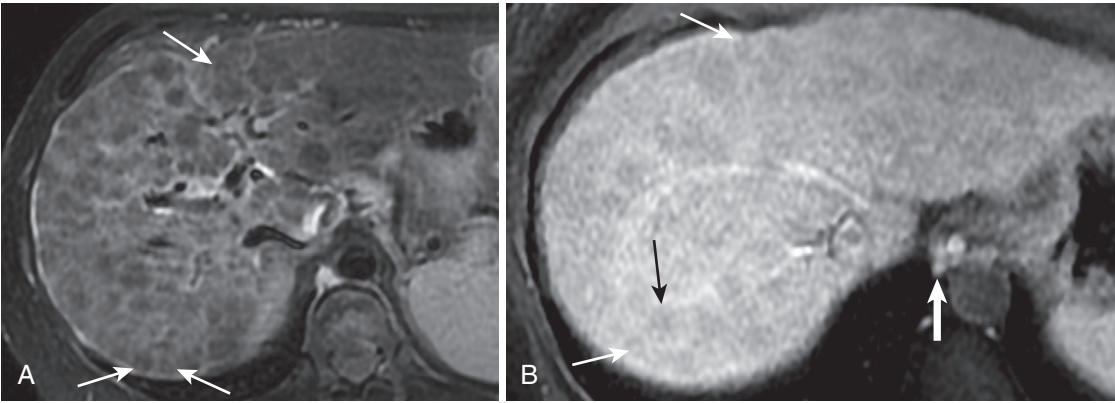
Periportal halo sign in PBC. Numerous hypointensities (*thin arrows* in A and B) surround central portal hyperintensities on the axial moderately T2-weighted fat-suppressed image (A) and enhanced image (B). Note the paraesophageal varices (*thick arrow* in B).
